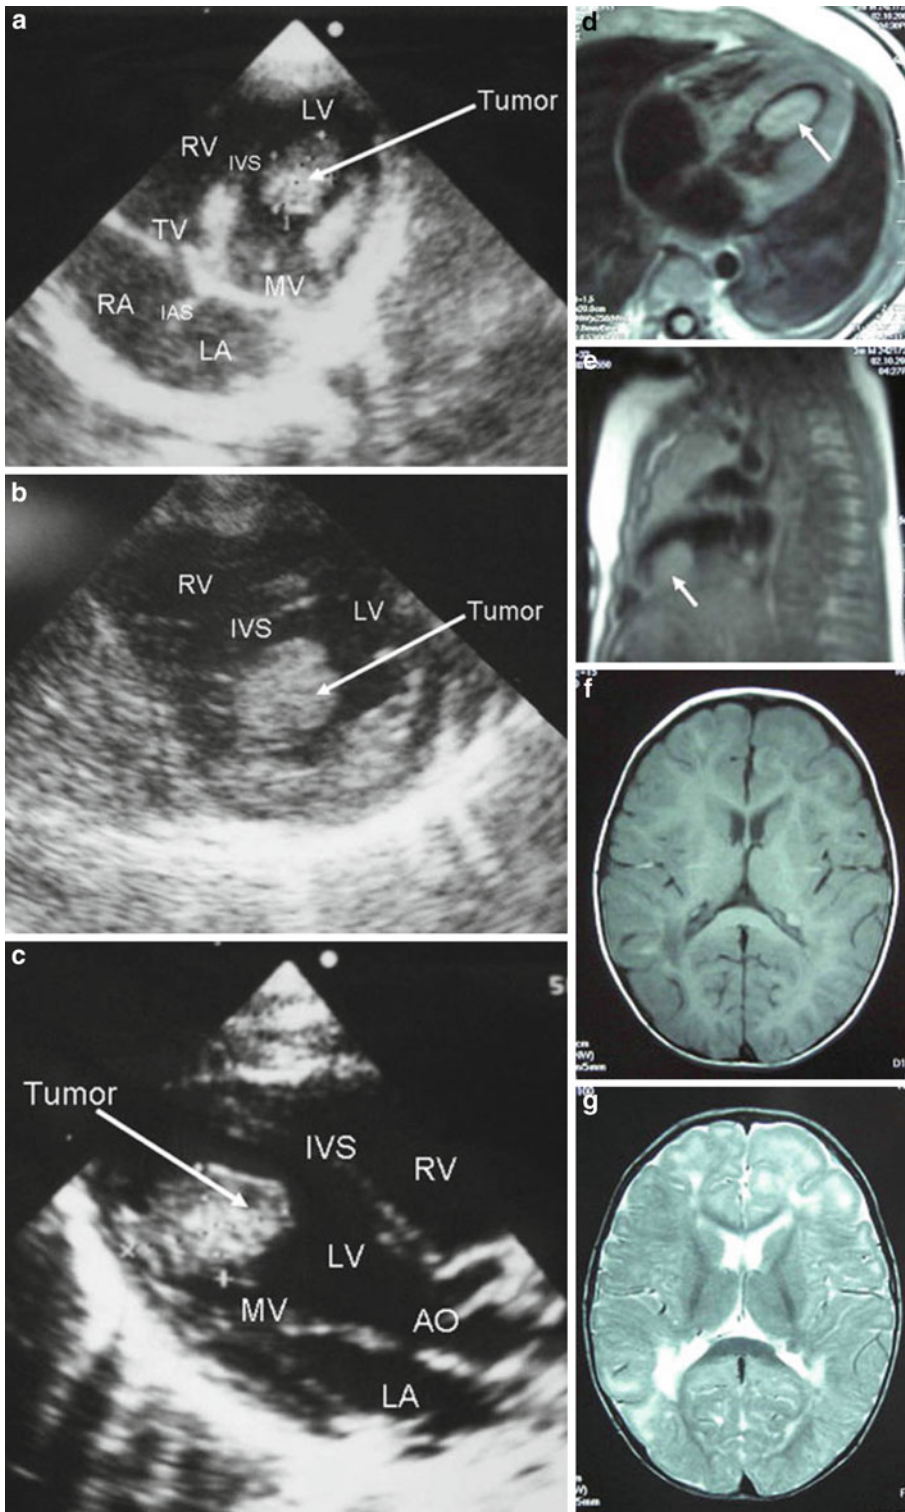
A 3-month-old infant was found to have small depigmented spots on the back, and a white round lesion in the left fundus. Echocardiography showed a tumor angiofibromatous skin lesions on the cheek, two
